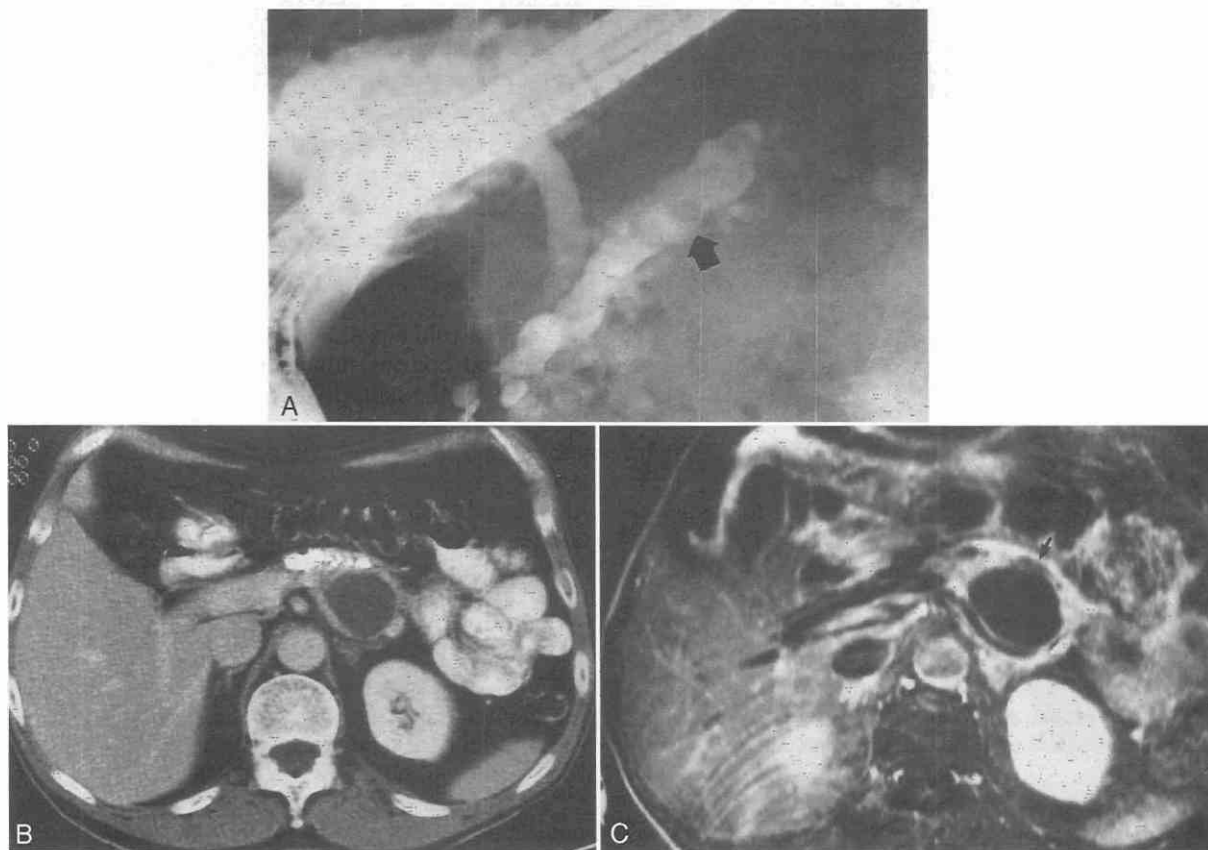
Chronic pancreatitis with pseudocysts. *A*, ERCP shows dilatation of the pancreatic duct (arrow) with calcifications throughout the pancreas. No communication between the duct and pseudocyst is shown. *B*, Contrast-enhanced, 5-mm CT scan shows extensive calcification along the wall of the pancreatic duct and clearly shows the pseudocyst arising from the posterior aspect of the body of the pancreas. *C*, Gadolinium-enhanced fast spin echo (FSE) (TR = 500 msec, TE = 15 msec) MR image clearly shows that the pancreatic duct (arrow) is anterior to the pseudocyst. Dilated duct and calcification could not be clearly distinguished. (From Semelka RC, Kroeker MA, Shoenut JP, et al: Pancreatic disease: Prospective comparison of CT, ERCP, and 1.5-T MR imaging with dynamic gadolinium enhancement and fat suppression. *Radiology* 181:785-791, 1991.)
